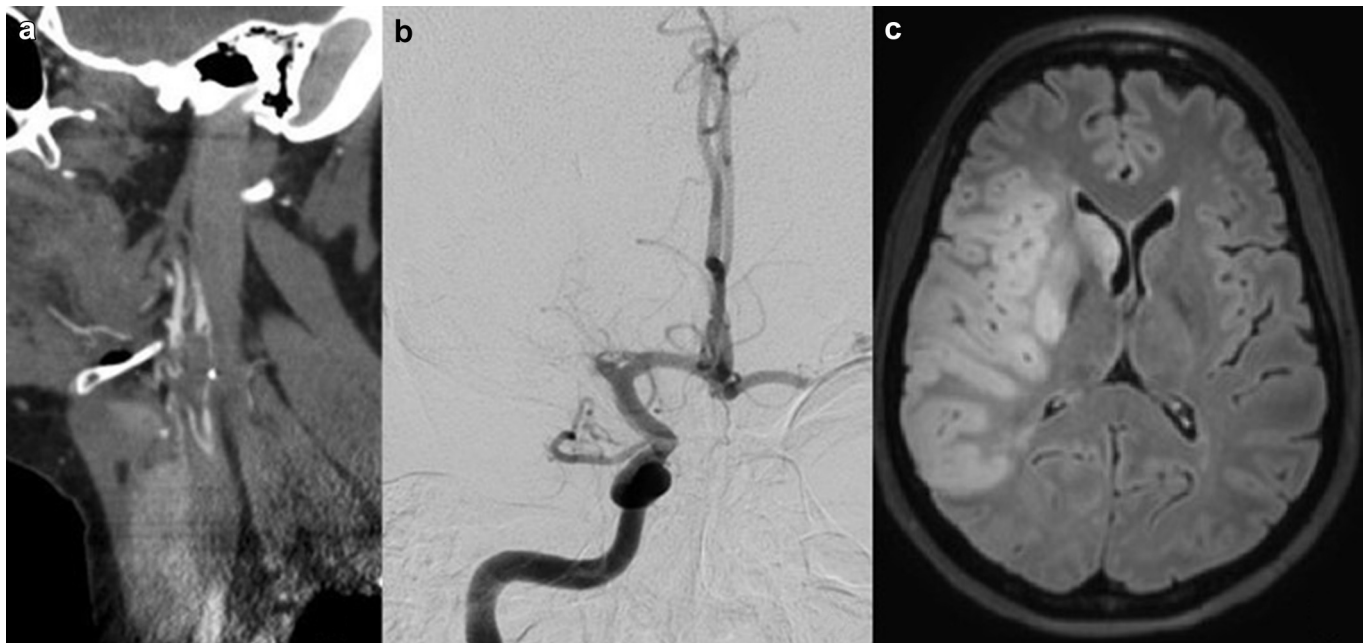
(a) Carotid computed tomodensitometry angiography showing a thrombus in the right external carotid bulb. (b) Angiography showing occlusion of the right middle cerebral artery. (c) Magnetic resonance imaging showing ischemic stroke in the territory of the right middle cerebral artery.
